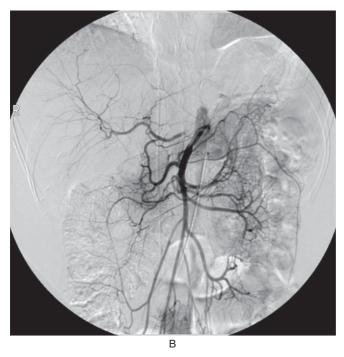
Arteriography with selective arterial calcium stimulation testing (SACS). A. Positioning of catheters for SACS. B. Angiogram of a patient with nonlocalizing transabdominal tumor. Ultrasonography, computed tomography, and endoscopic ultrasonography suggest a lesion in the tail of the pancreas (faint "blush" from the dorsal pancreatic artery branch from the SMA = superior mesenteric artery; *). C. Insulin levels in the hepatic vein after selective calcium injection of the GDA = gastroduodenal artery, SMA, and splenic arteries in the same patient demonstrate a marked insulin increase with injection of the SMA, confirming angiographic findings. The patient was taken to the operating room, and the tumor was confirmed by intraoperative ultrasonography and enucleated. The patient was cured.
